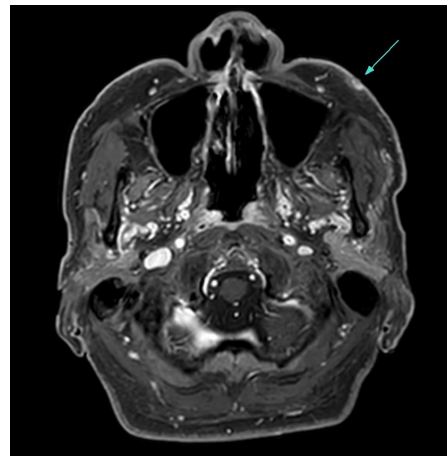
T1 axial view of contrast-enhanced neck magnetic resonance imaging showing a 6 × 7 × 3 mm size lesion in the left anterior cheek. No enlarged lymph nodes were found.
